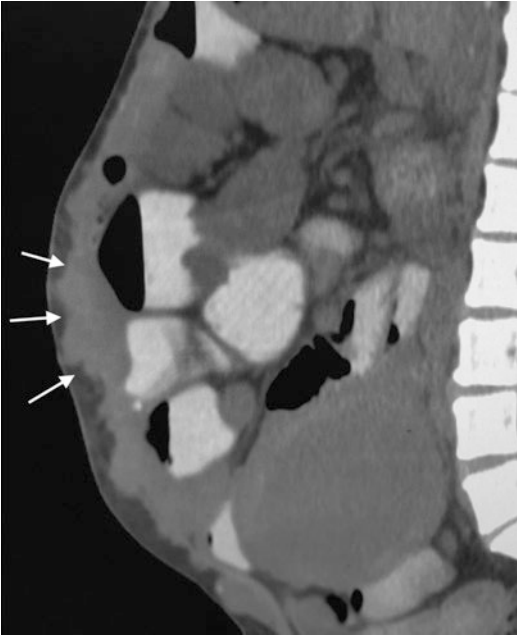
CT image showing diffuse recurrence in a patient with pseudomyxoma peritonei post-cytoreductive surgery and HIPEC. Tumor is infiltrating the anterior abdominal wall as well as the bowel wall
